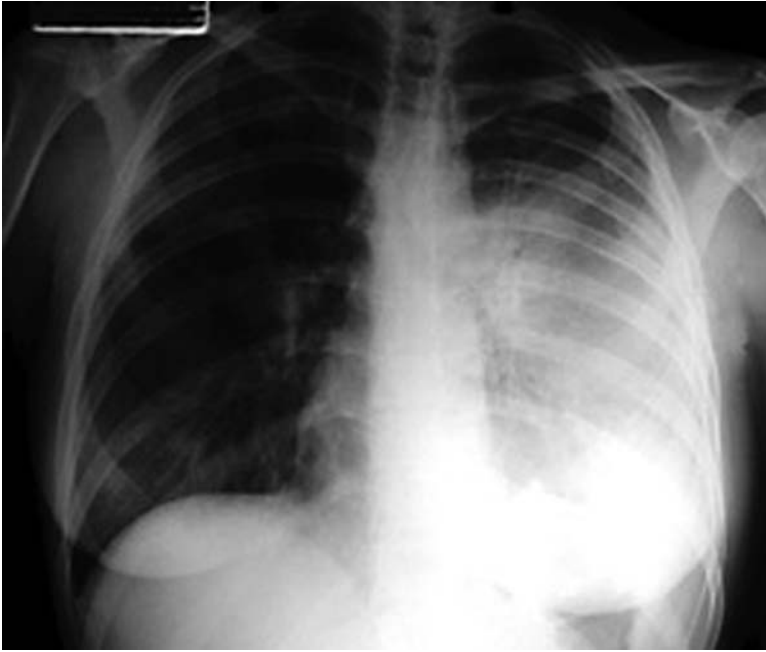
Chest X-ray of plague, with dense consolidation within left lung. (Reprinted from ref. 22.)
